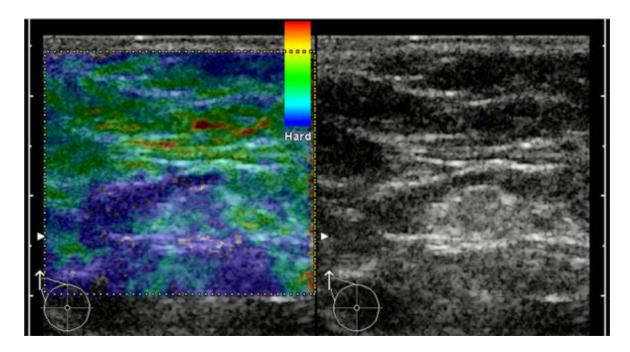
Wojcinski et al, 2012, in reference [11]. Open Access. Example for B-mode ultrasound and elastogram of a metastatic LN. In B-mode ultrasound, the cortex of the LN is slightly enlarged (maximum ~3.5mm). The predominant color of the medulla is turquoise (to green) and the cortex is mainly blue. Meeting both criteria of cortex >3mm in B-mode AND blue cortex in the elastogram, this case would be a true-positive.
